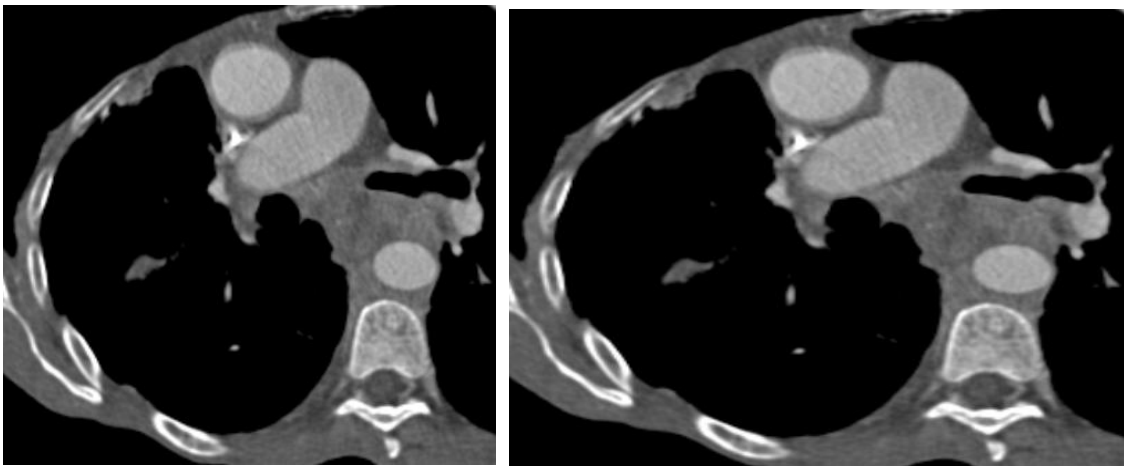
Axial CT scan showing a tissue tumor process budding the middle third of the esophagus.
